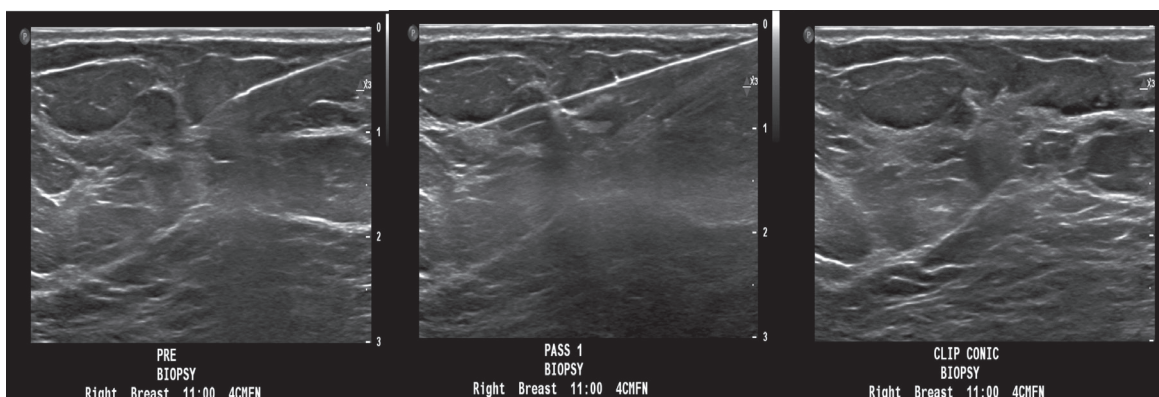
Ultrasound of the right breast demonstrating a hypoechoic mass at the 11 o'clock location, followed by U/S guided biopsy and clip placement of the same mass.
